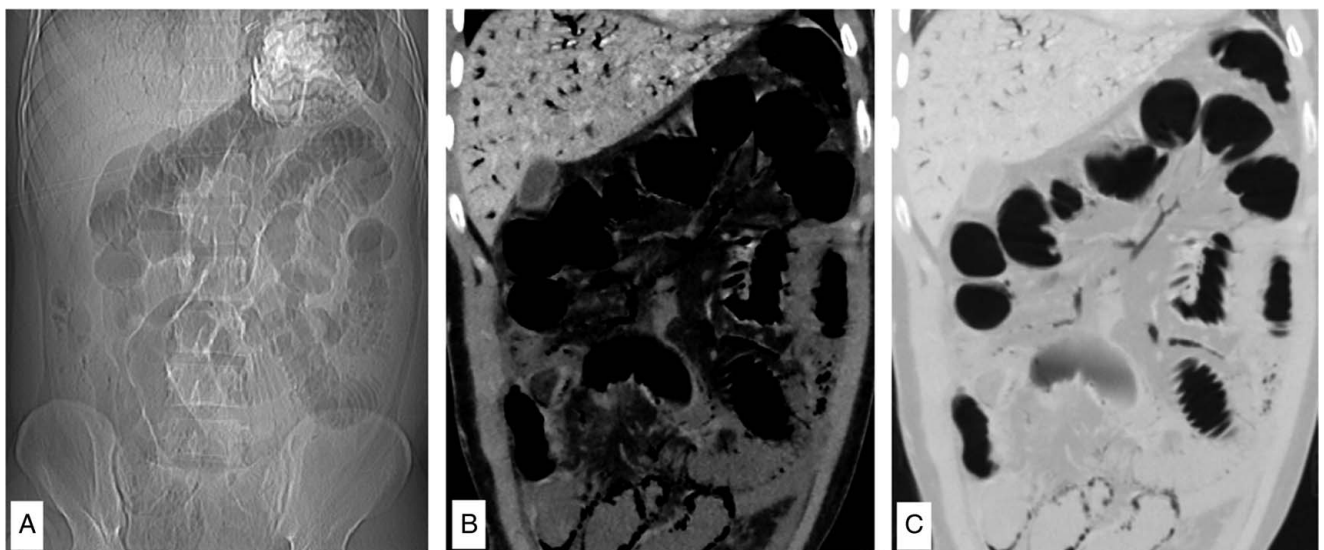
Computed tomography scout image of the abdomen (A) shows multiple linear branching lucent areas along the liver shadow, which is suspicious for ‘portal venous gas’; multiple linear dark foci are also noted along the contour of small bowel loops in the lower abdominal region which is suspicious for ‘pneumatosis intestinalis.’ Coronal contrast-enhanced computed tomography image of the abdomen in soft tissue window (B) shows the presence of air attenuating areas along the contour of the small bowel wall in the lower abdominal region, which is ascertained by corresponding dark areas in the lung window computed tomography image (C) confirming the presence of mural gas, i.e. ‘pneumatosis intestinalis’; (B, C) also demonstrate linear air attenuating areas in liver extending up to the periphery which is suggestive of ‘portal venous gas’; coronal lung window image (C) also shows linear dark areas in the region of small bowel mesentery consistent with the presence of ‘gas in mesenteric veins.’
